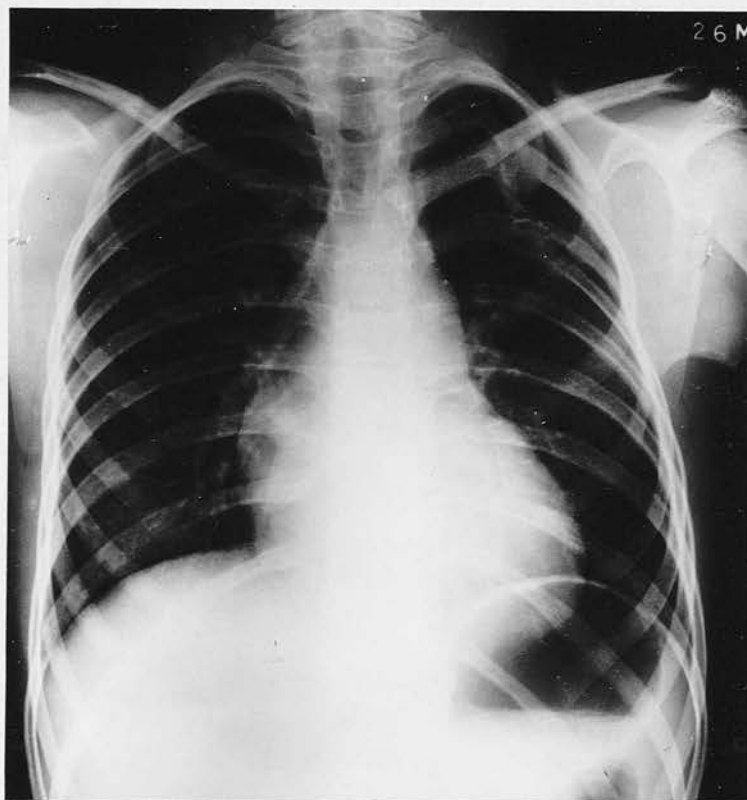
Radiograph of Case 39. Pulmonary Aneurysm. Further follow-up.
